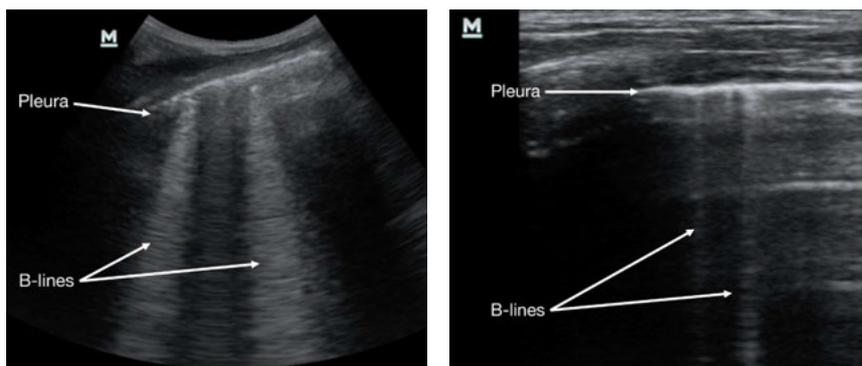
Convex (L) and linear (R) ultrasound scans demonstrating vertical, laser-like B-lines
